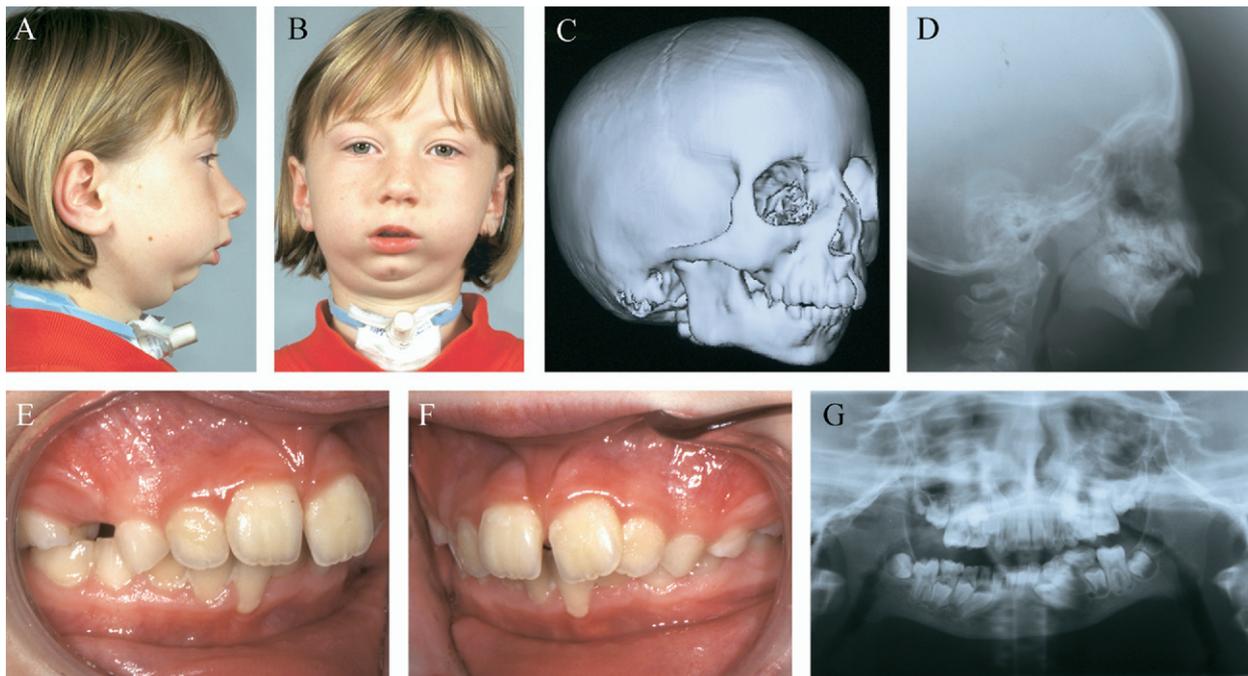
Predistraction records age 9 years: A and B, facial photographs; C, 3-dimensional computed tomography scan; D, cephalometric radiograph; E and F, intraoral photographs; G, panoramic radiograph.
